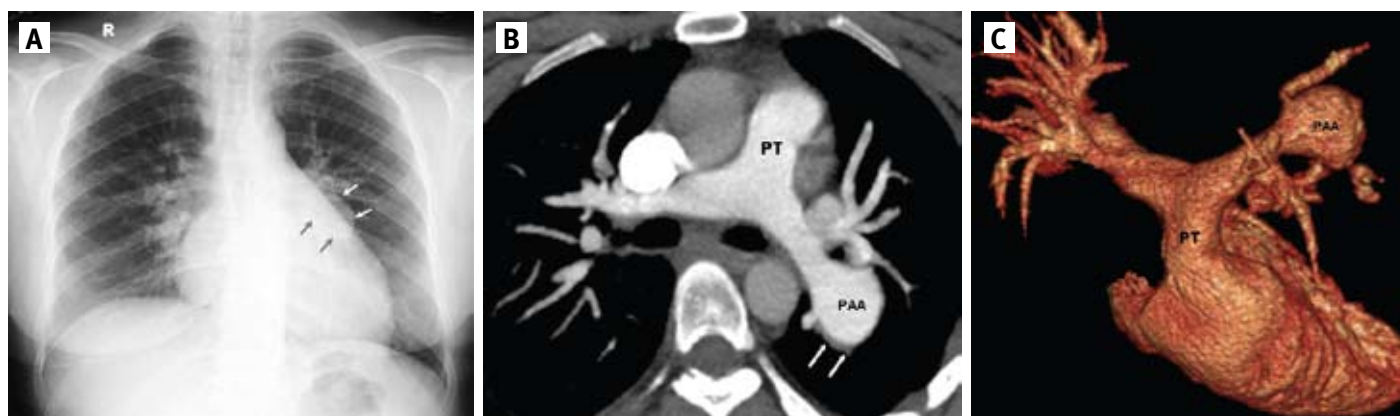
Pulmonary artery aneurysm in a 39 year old asymptomatic woman. [A] Chest radiograph show left hilar enlargement (arrows) and normal lungs. Contrast-enhanced axial [B] and 3D volume rendering [C] CT images show saccular aneurysmal dilatation of the left inferior lobar pulmonary artery with small mural thrombi (arrows). PAA = pulmonary artery aneurysm, PT = pulmonary trunk.
